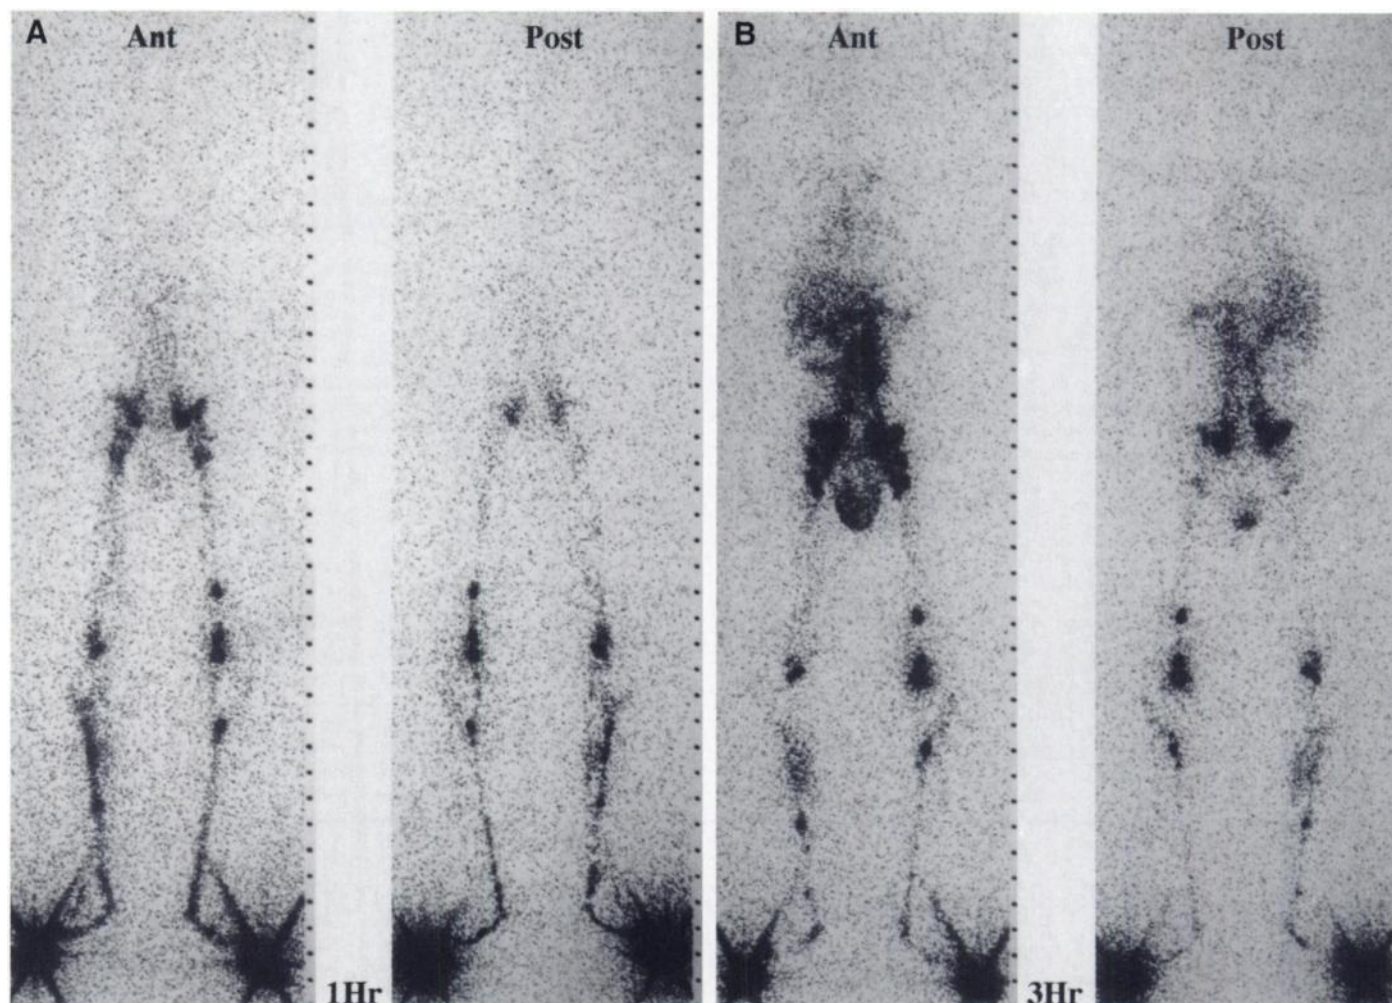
(A) Lymphoscintigraphy at 1 hr shows radiotracer at injection sites in both feet and relatively symmetrical, rapid radiotracer uptake in inguinal regions bilaterally. Mild diffusely abnormal radiotracer distribution is seen in pelvis and scrotum consistent with lymphangiectasia. In addition, unusual pattern of multiple discrete lymph nodes seen along lymphatic channels of lower extremities is of uncertain significance. No radiotracer activity is seen in liver, indicating delayed flow of lymph from dilated pelvic and thoracic lymphatic channels into venous circulation. (B) Lymphoscintigraphy at 3 hr shows avid radiotracer uptake in iliac lymphatics, and refluxing radiotracer is seen in scrotum, perineum, retroperitoneal and very likely in mesenteric lymph vessels. More diffuse radiotracer uptake is seen in central abdomen and thorax consistent with lymphangiectasia. Liver is now visualized, indicating free passage of radiotracer from lymphatics into systemic circulation. Persistent uptake of radiotracer is seen in unusual pattern of lymph nodes in lower extremities.
